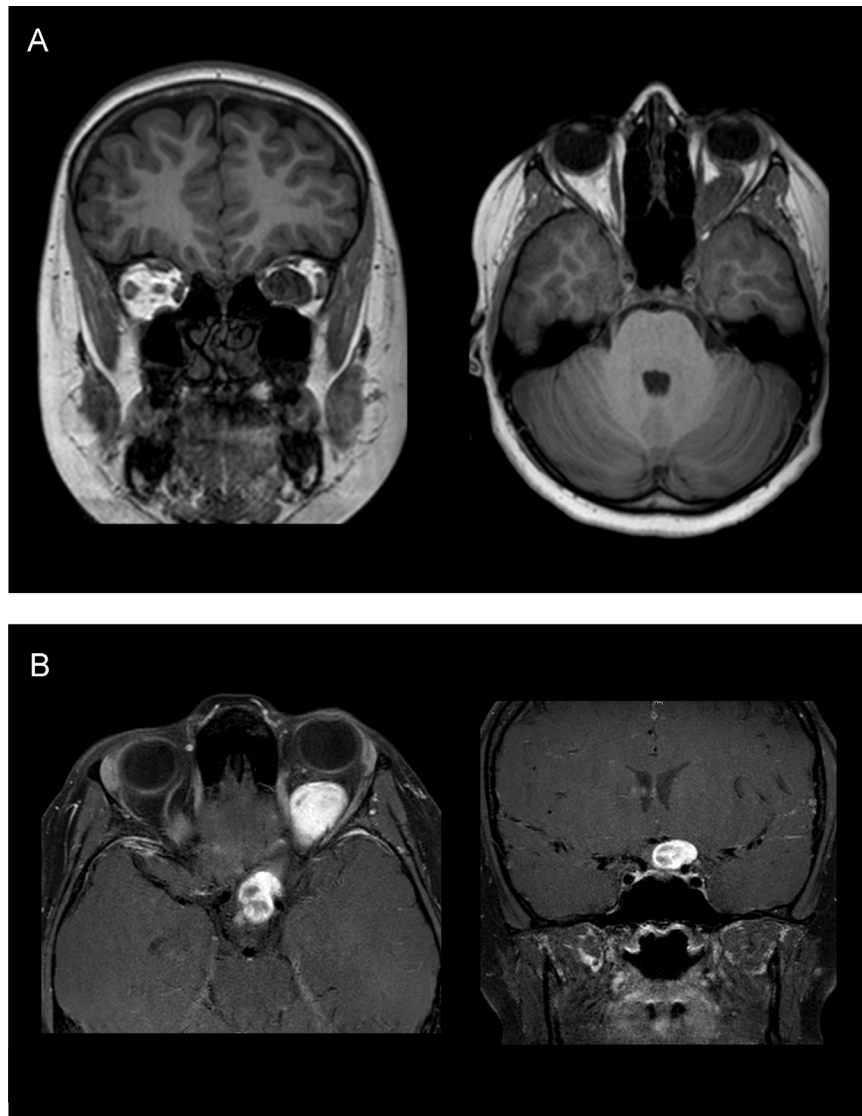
(A) Magnetic resonance imaging (MRI) T1 coronal and axial views at presentation demonstrating intraconal tumour involving the optic nerve OS. (B) MRI T2 with contrast, axial, and coronal views 9 months after the start of chemotherapy demonstrating tumour growth and posterior extension.
